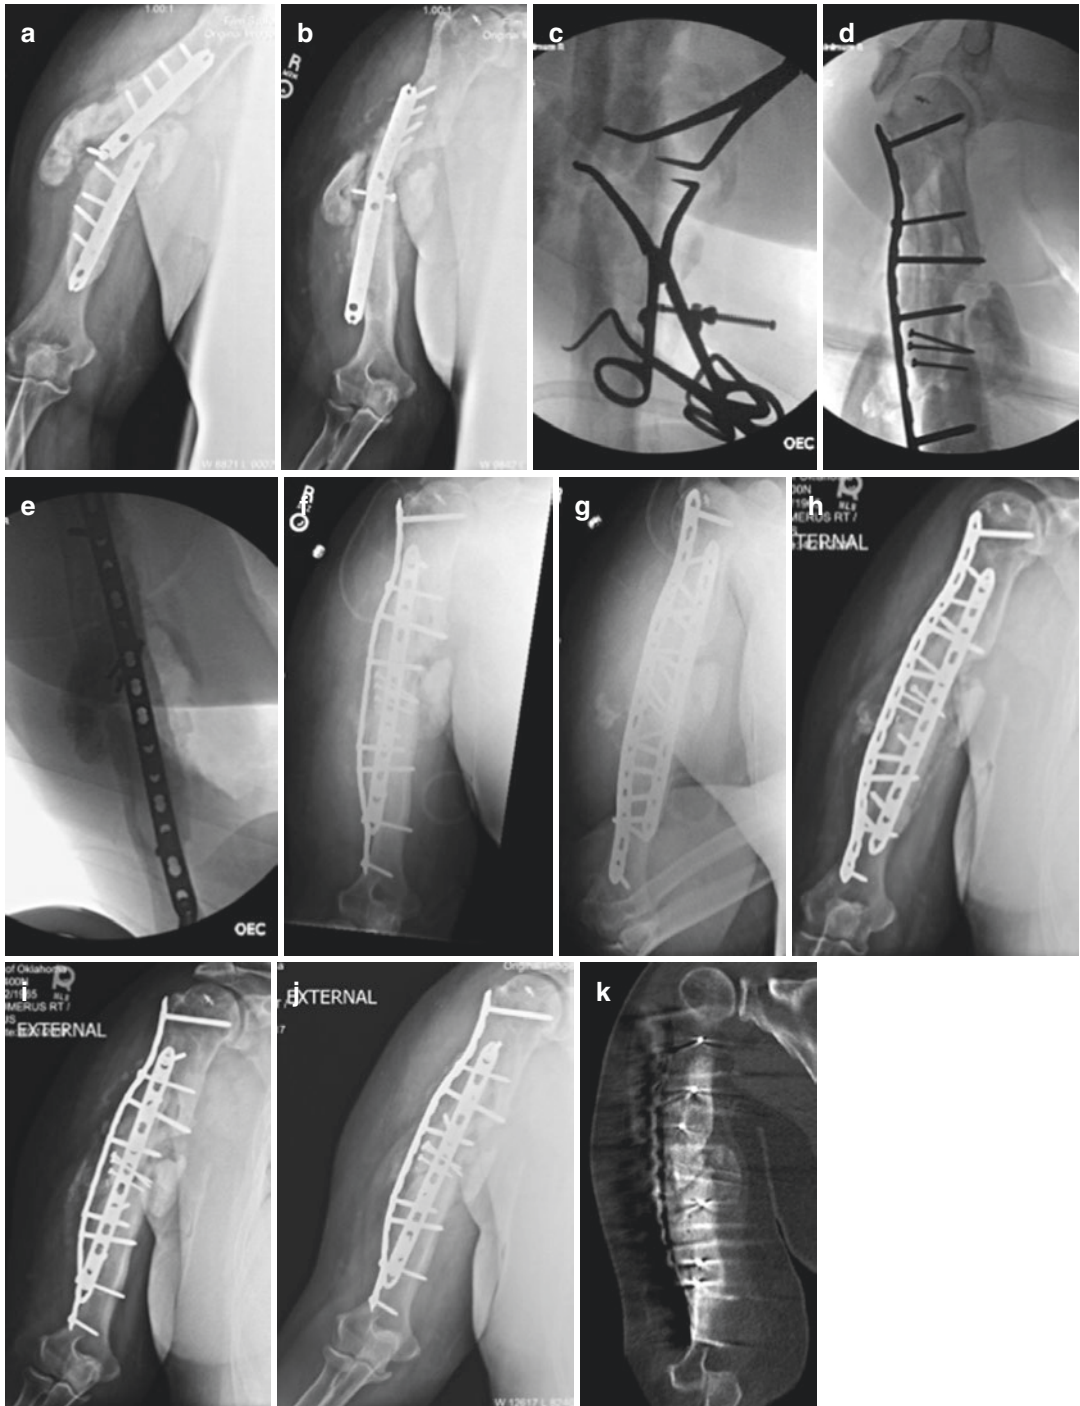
Anteroposterior (AP) (a) and oblique (b) radiographs of a hypertrophic humeral shaft nonunion with failed plate. (c–e) Intraoperative fluoroscopic images during the repair of this nonunion. Inter-fragmentary compression between the fracture fragments is obtained with pointed reduction forceps and then lag screws. Large fragment neutralization plates are applied to provide additional stability and to protect the lag screws. Immediate
